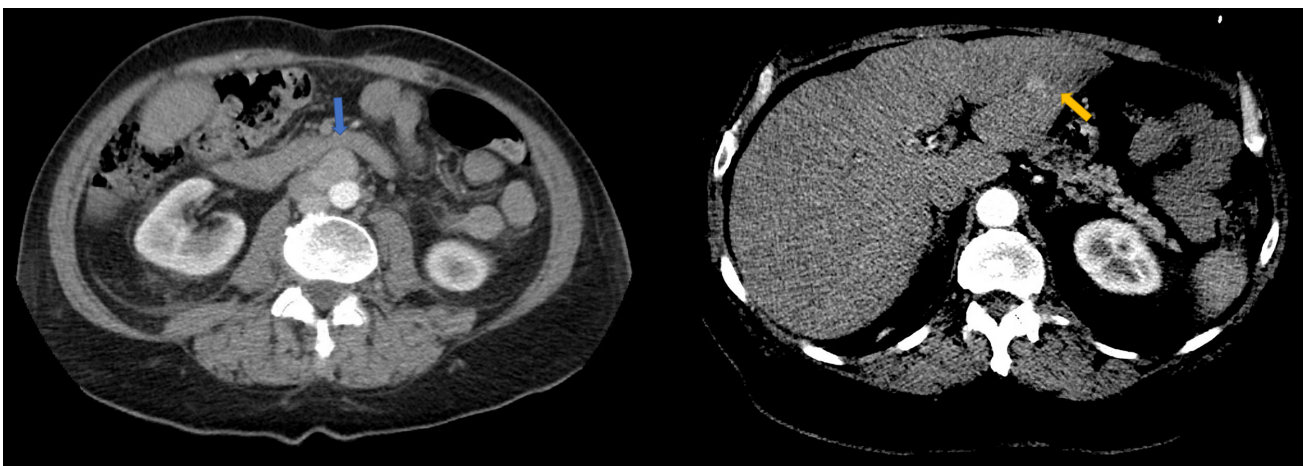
Axial section of the CT abdomen demonstrating intra-abdominal lymphadenopathy (blue arrow) and a 1 cm lesion in the left hepatic lobe (yellow arrow)
